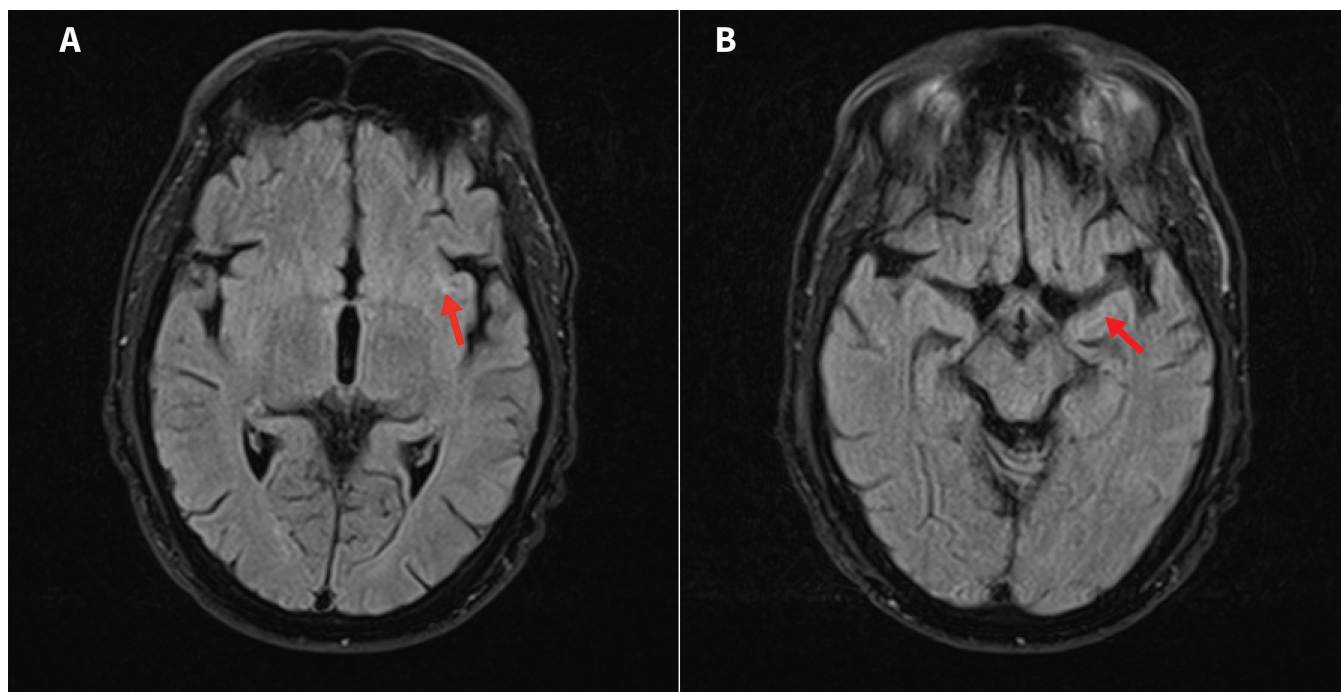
Magnetic resonance imaging scan of the patient's brain, including T_2 fluid-attenuated inversion recovery axial slices showing increased signal in the (A) left insular and (B) mesial temporal regions. Motion artifact present.
